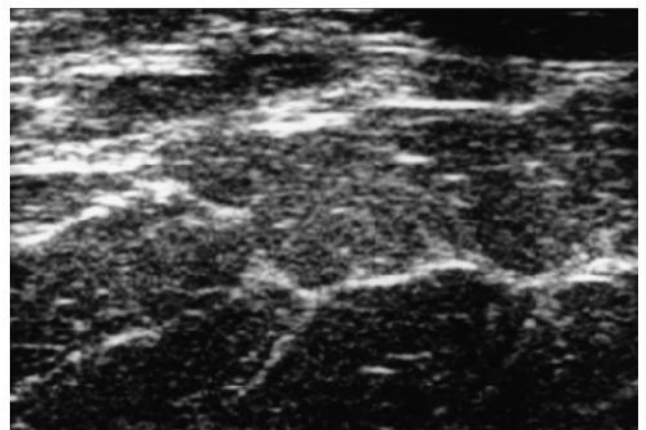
An ultrasound (US) of an obese pseudogynecomastia 12 year-old boy showing accumulation of adipose tissue in the breast
